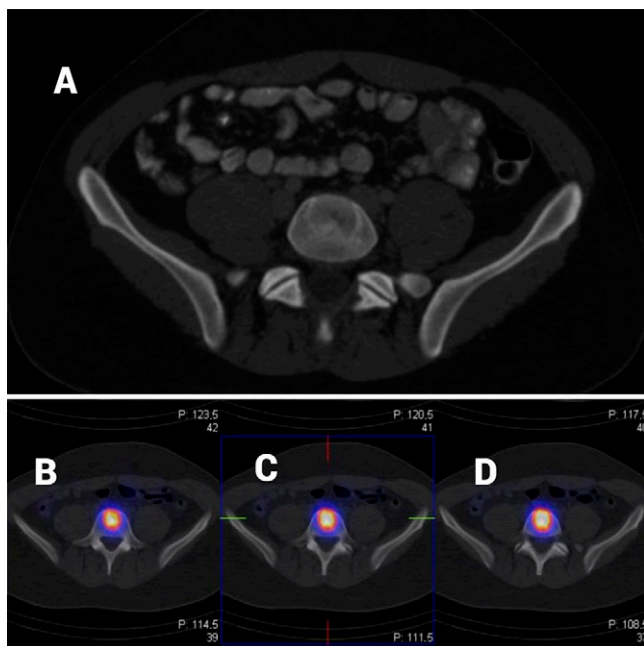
A: Axial image of CT through the L5 vertebral body showing an isolated anterior-sided lesion in the vertebral body, with no effect on the posterior arch. B–D: Axial images of the ¹¹¹In-pentetreotide scintigraphy showing pathological caption of the tracing in L5 vertebra, compatible with tumoral effects with somatostatin receptors.
